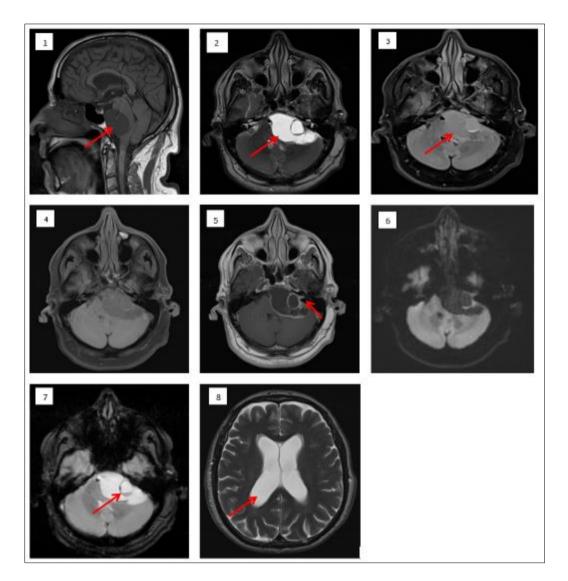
Voluminous mainly cystic extraaxial lesion, located on the left cerebellopontine angle, moderately hypointense on T1-weighted images (1, arrow), with a liquid hypersignal on T2-weighted images (2, arrow), which didn't disappear on FLAIR sequence (3, arrow). No modification was seen on FAT SAT (4). Small solid enhanced contingent (E, arrow), developed in the internal auditory canal, causing an enlargement of the porus, and extended into the cerebellopontine angle. Diffusion (6) showed no restriction and the apparent diffusion coefficient (ADC) was high. Hemorrhagic stigmata revealed on T2* (7, arrow), T2 (2) and FLAIR sequences (3), with a fluid-fluid level
